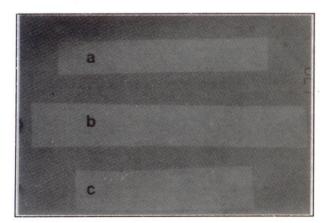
The three strips of foil were radiographedon dental film and by conventional dental X-ray machine.
